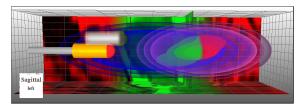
The target closeup visualization shows the potential target regions (speech tests=blue, movement tests=purple). The spatial context provided by the MRI signal is color coded using the red-green MER region mapping. The stimulation electrode changes its color when entering the intersection of the potential target area. This view gives qualitative access to all uncertainty data fused with structural data in one glance. In addition, the x-ray scan based reconstruction of the electrode's position is shown in grayscale.
